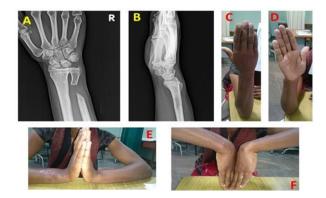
Functional outcome modified Sauve-Kapandji procedure. Radiographs and clinical pictures post implant removal after 2 years. (A, B): Anterio-posterior and lateral radiographs of wrist of fusion at DRUJ. (C, D): Supination and pronation of forearm. (E): Dorsiflexion of wrist. (F): Palmarflexion of wrist.
